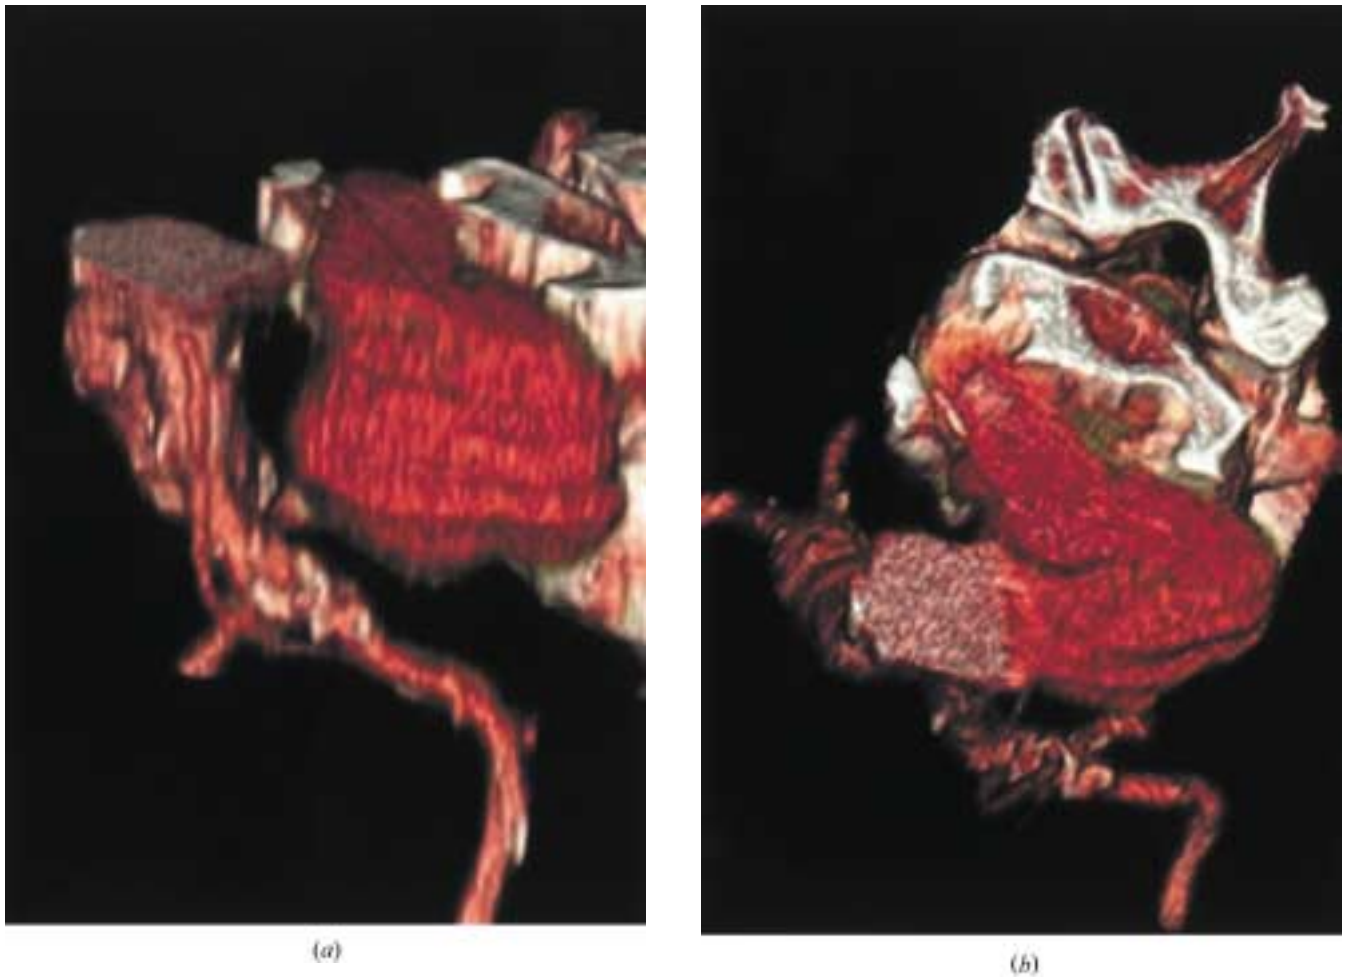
3D Volume Rendering (VR) reconstruction of the volumetric spiral CT data set. Parameters of VR reconstruction have been chosen to show only contrast enhanced patent lumen of the pseudoaneurysm, excluding its hypodense thrombosed portion. Lateral view (a) of 3D VR reconstruction allows precise anatomical localizing of the site of AAA rupture and shows the relationship to the spine. Left antero-lateral cranial view (b) of the VR reconstruction at the level of the fourth vertebral body better defines the bony erosion and its relationship to the pseudoaneurysm and may be helpful in surgical planning.
